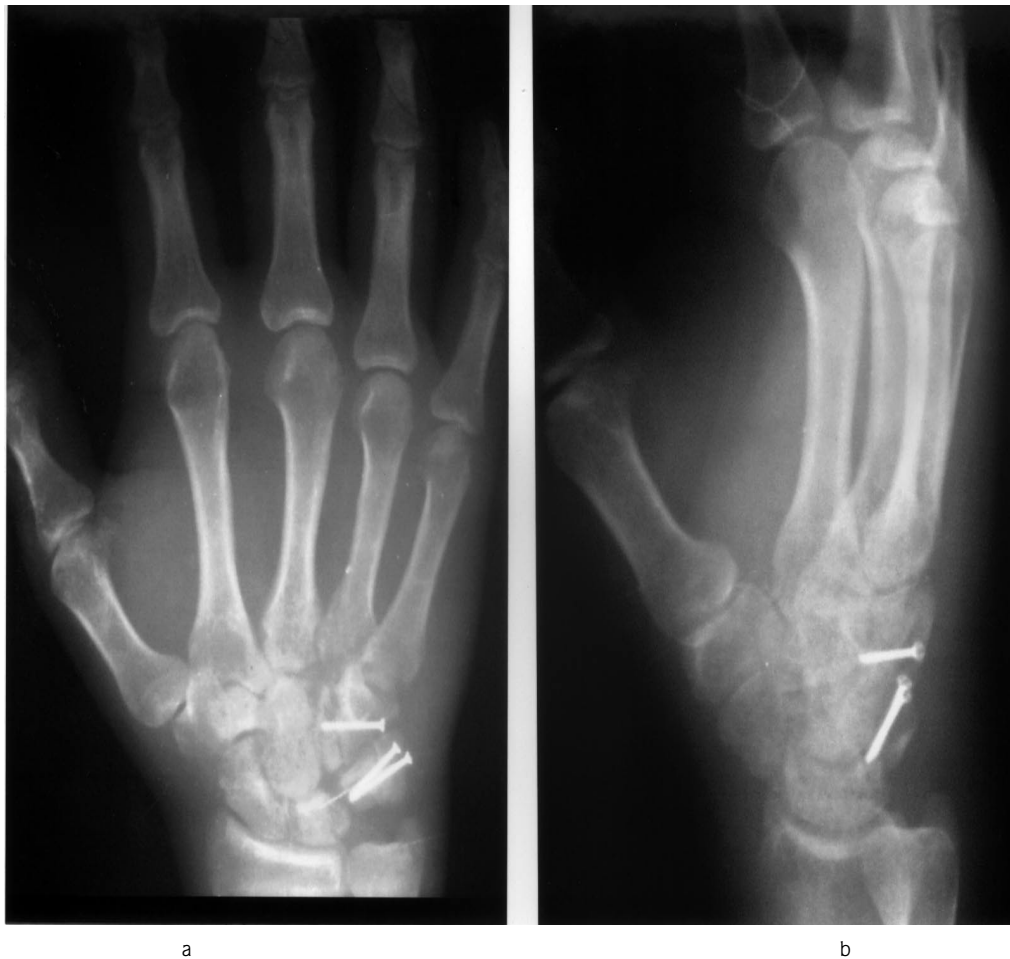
Early postoperative X-rays showing the location of the lag screws. a) P-A, b) lateral.
